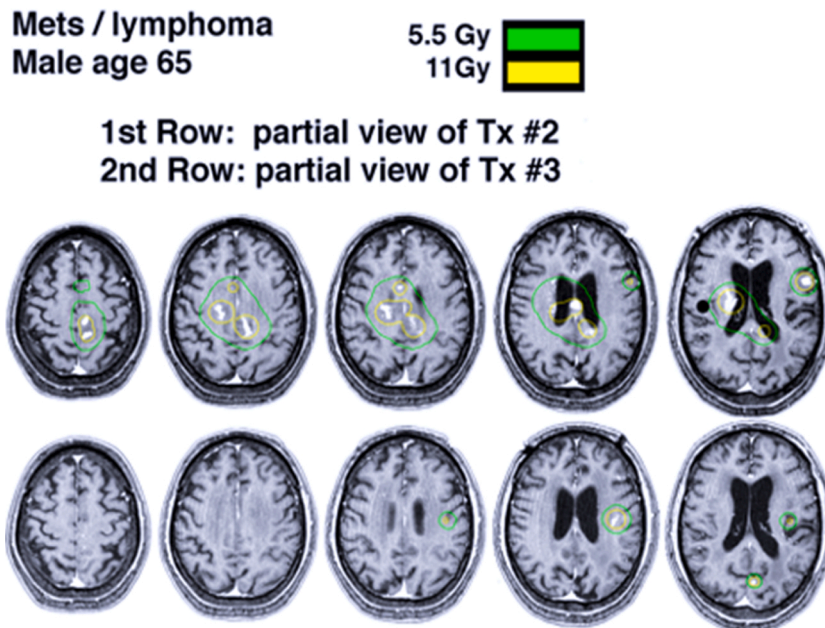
Brain MRI for gamma knife surgical plan. The image shows total tumor control in brain MRI follow-ups. Gamma Knife surgery should be performed for tumor control as a part of the initial treatment of PCNSL. It is noninvasive, safe, and its effects occur rapidly. Its use improves prognosis and enhances the patient’s quality of life.
